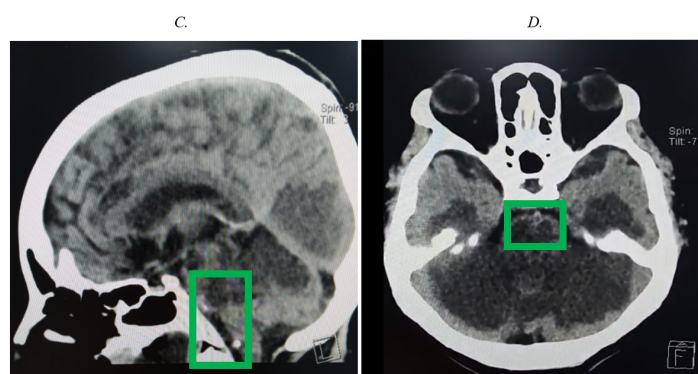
Simple cranial CT C. In the sagittal plane in the frame, hyperdense sign is observed with hyperdensity of the basilar artery in its middle third. D. In the axial plane, extensive infarction of the pons and cerebellum is observed.
